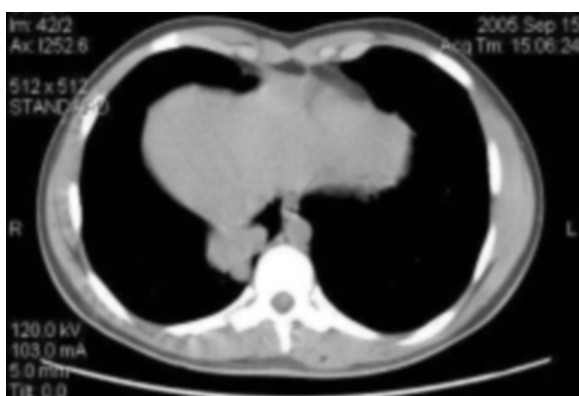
Axial CT image in soft tissue settings demonstrates an ill-defined opacity adjacent to the right hemidiaphragm.
